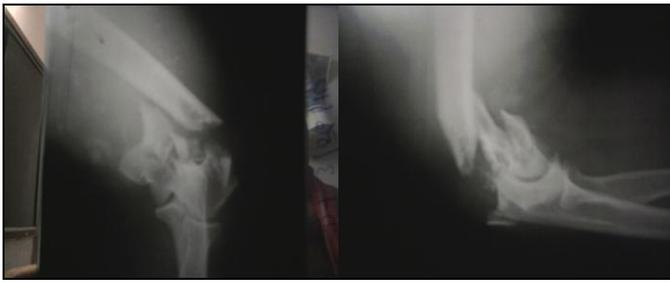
Showing Preoperative X-rays of case 1 (AP& Lateral)
